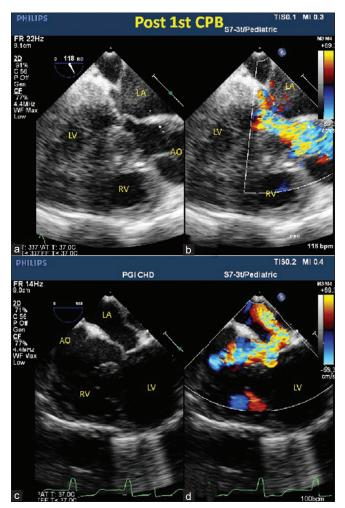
TEE after resection of subaortic membrane. (a and b) ME aortic long-axis view showing a narrow left ventricular outflow tract; color doppler assessment shows turbulence originating at the point of contact of anterior mitral leaflet with interventricular septum. (c and d): ME 5-chamber view with 2-D image and color doppler assessment showing severe mitral regurgitation and turbulent flow across left ventricular outflow tract originating at the point of contact of anterior mitral leaflet with interventricular septum (LA: left atrium; LV: left ventricle; RV: right ventricle; AO: aorta)
